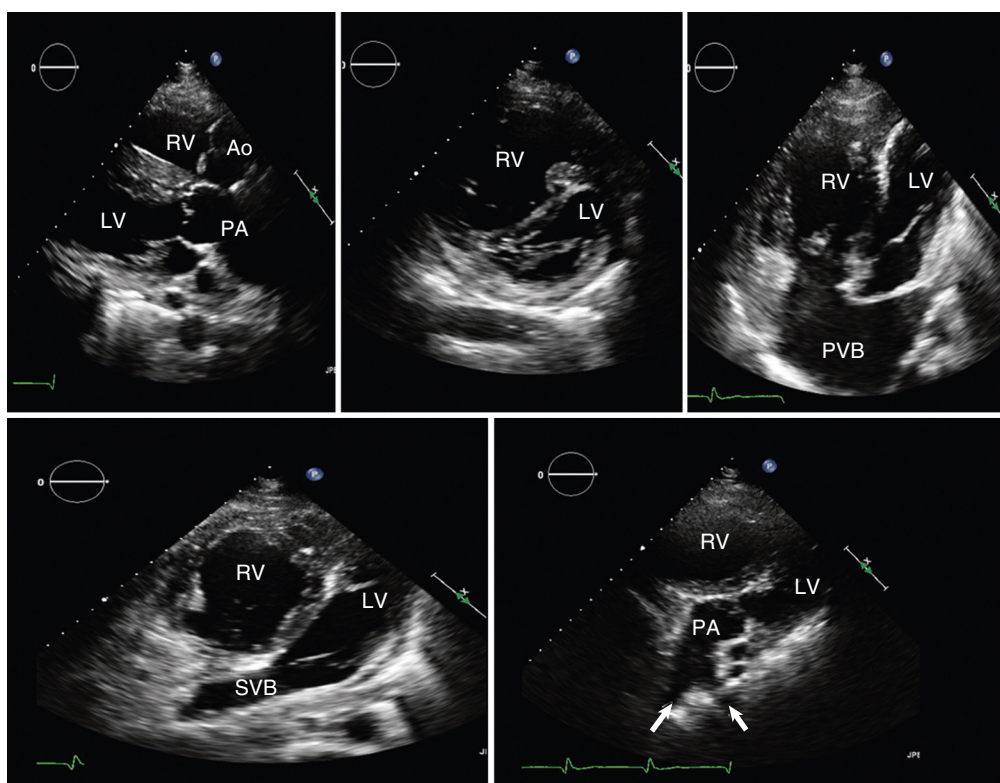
D-Transposition of the great vessels after Mustard baffle surgery. Top left, Parasternal long-axis view showing parallel orientation of the aorta (Ao) and pulmonary artery (PA). The aorta is anterior. Top middle, Parasternal short-axis view showing septal inversion reflecting the fact that the right ventricle (RV) is the systemic ventricle. Top right, Apical four-chamber view showing the pulmonary venous baffle (PVB), which directs pulmonary venous flow across the tricuspid valve into the RV. Bottom left, The four-chamber view has been angulated to demonstrate the systemic venous baffle (SVB), which directs systemic venous return across the mitral valve into the left ventricle (LV). Note the right ventricular hypertrophy and enlargement. Bottom right, The four-chamber view is angulated anteriorly to demonstrate the connection between the LV and PA. Arrows point to the PA bifurcation.
